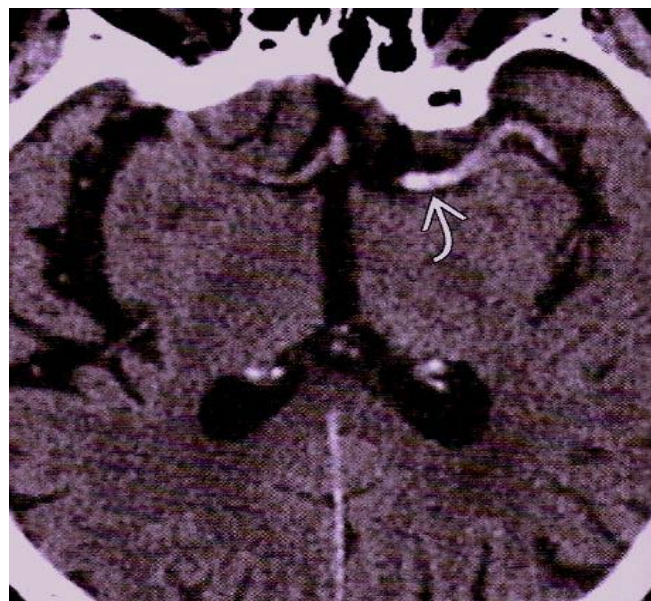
16 Axial non enhanced CT demonstrates right MCA ➔ due to thrombus occluding the vessel (Diagnostic Imaging Cardiovascular, 2008: pII-1-49)
